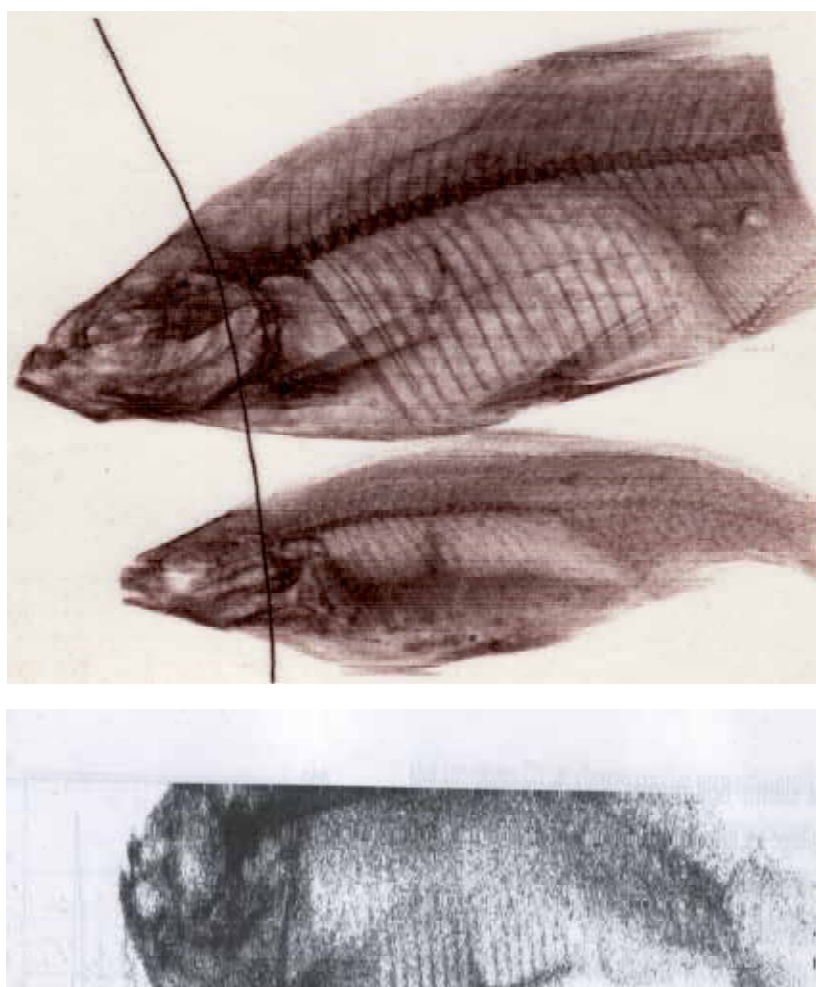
The X-ray images of fishes. Left image is received by the bilinear detector with 800 μm pitch, right image is received by the pin-diode detector with the 200 μm pitch.
